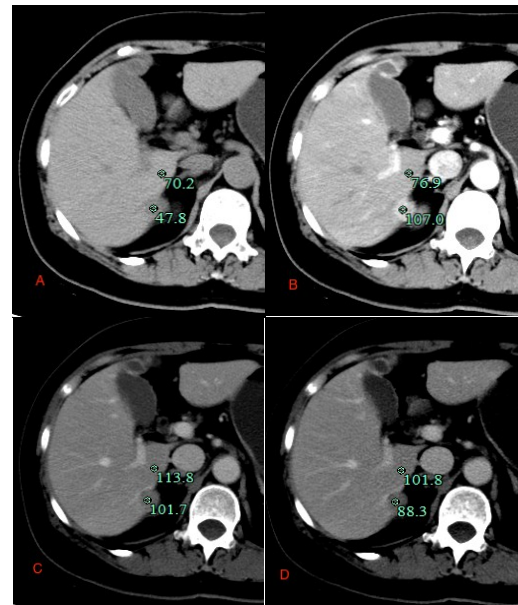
Images in a 55-year-old man with SHCC. The CT enhanced scan of liver shows: there is a round low - density lesion with the size of approximately 1.5 cm * 1.5 cm, uniform density, a clear boundary in the hepatic VI segment; and the lesion of AP (B) is obviously uniform enhanced with high - density (Δ HU =30.10HU, CVR=1.39), the enhancement was reduced in PP (C) and DP (D) to low-density, and the Δ HU are -12.10HU, -13.50HU and CVR are 0.89, 0.87, respectively. CVR: CT value ratio, SHCC: small Hepatocellular Carcinoma, Δ HU: CT value difference, AP: arterial phase, PP: portal phase, DP: delayed phase.
